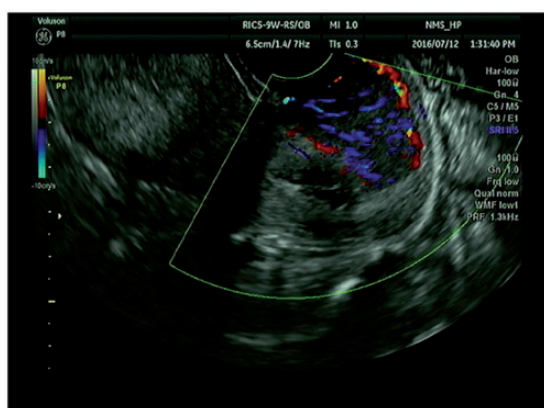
Transvaginal ultrasonography showed a hypervascular mass.
